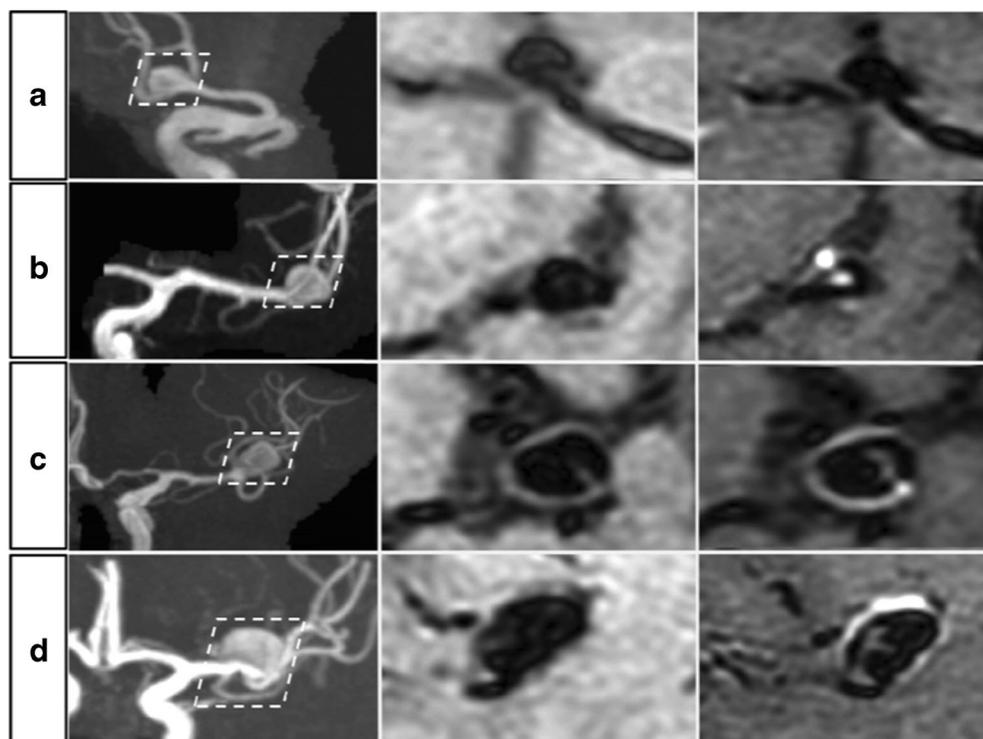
Reprinted with permission from Edjlali et al., Radiological Society of North America [89•]. “Grading of aneurysm wall enhancement. For each aneurysm represented on a row, a 3D time-of-flight MRA is shown in the left column, a 3D T1-weighted fast-spin-echo image is in the middle column, and a 3D T1-weighted fast-spin-echo image obtained after enhancement with gadolinium chelate is shown in the right column. a Grade 0: non-enhancing anterior communicating artery aneurysm. b Grade 1: focal thick wall enhancement of a middle cerebral artery aneurysm. c Grade 2: thin and circumferential wall enhancement of a middle cerebral artery aneurysm. d Grade 3: thick (> 1 mm) and circumferential wall enhancement of a middle cerebral artery aneurysm. Focal enhancement greater than 1 mm within otherwise thin circumferential aneurysmal wall enhancement was grade 3.”
